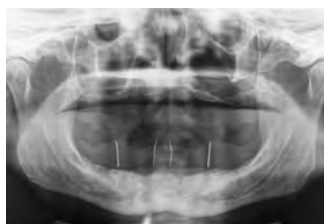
Panoramic radiograph confirms adequate positioning of proposed implant sites
